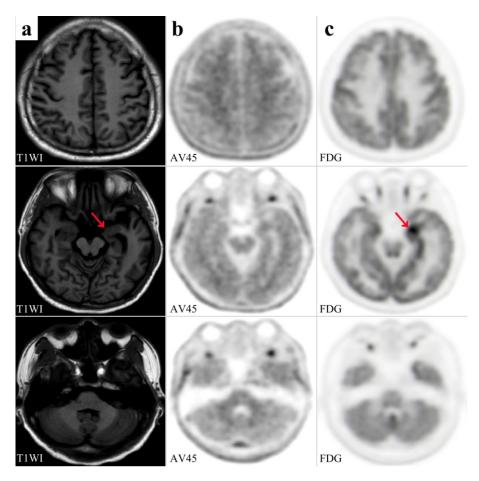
A 37-year-old male with memory loss for 3 years, aggravated for 1 month accompanied by mood and mental behavioral abnormalities, had scores of 21/30 on the Montreal Cognitive Assessment (MoCA). On admission, the patient's serological tests were positive for *Treponema pallidum* particle agglutination test (TPPA) and toluidine red unheated serum test (TRUST); cerebrospinal fluid (CSF) showed elevated white blood cells and protein, and positive venereal disease research laboratory (VDRL) and TPPA tests. Brain magnetic resonance imaging (MRI) showed diffuse white matter hypointensity, mild cerebral atrophy, with more pronounced atrophy of the left hippocampus (a, arrow). Furthermore, the patient's CSF Aβ1-42 decreased and T-Tau increased, while Aβ1-42/Aβ1-40 and P-Tau were in the normal range. Subsequently, brain fluorine-18 (18 F)-Florbetapir positron emission tomography/computed tomography (PET/CT) scan was performed, which showed reduced contrast and blurred borders in the grey and white matter of the cerebrum and cerebellum, i.e. weakly positive for amyloid deposits in the cerebral and cerebellar cortex (b). And brain 18 F-fluorodeoxyglucose (FDG) PET/CT showed hypermetabolism in the left hippocampal region (c, arrow). Besides, apolipoprotein E (APOE) genotyping revealed the ε2/ε3 genotype, and whole-exome sequencing excluded mutations in APP, PS1 and PS2, arguing against coexistent genetic Alzheimer's disease (AD). Finally, the patient was diagnosed with neurosyphilis related dementia i.e. general paresis of the insane (GPI). After 4 weeks of penicillin treatment and follow-up, the patient complained of improved memory and mood, with MoCA scored 23/30.
